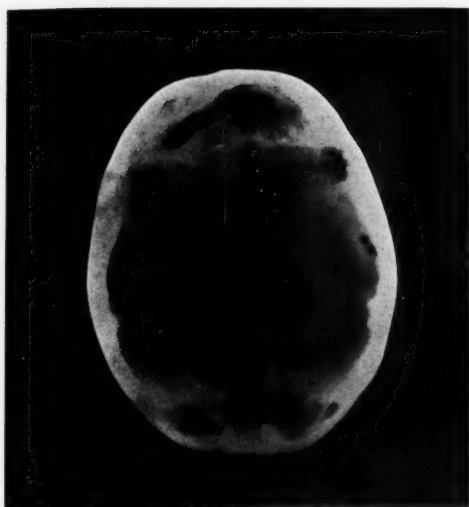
X-ray film of skull cap showing multiple lesions which involve both tables.
